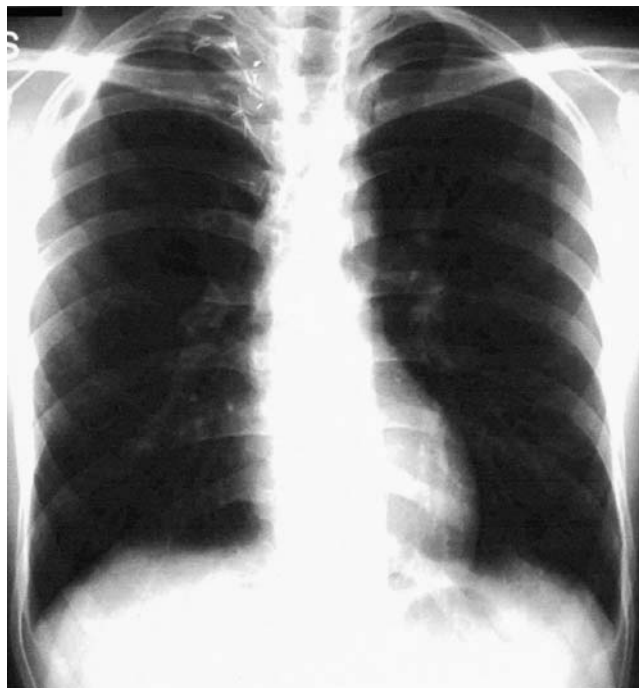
Postoperative chest radiograph, taken about 4 h after the first attempt at inserting the epidural catheter, detected a left-sided pneumothorax
